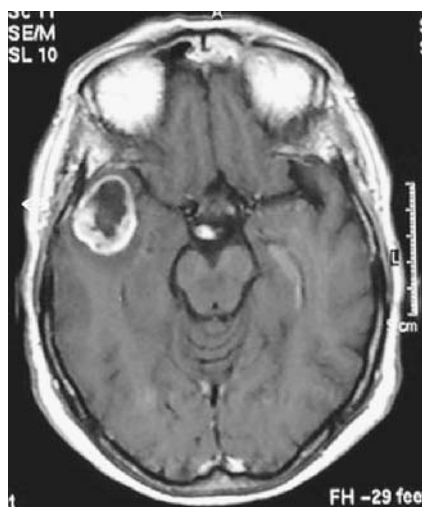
Case 1. MRI showing a roundish neoplasm in the right, temporal site enhancing disomogeneously after contrast administration
